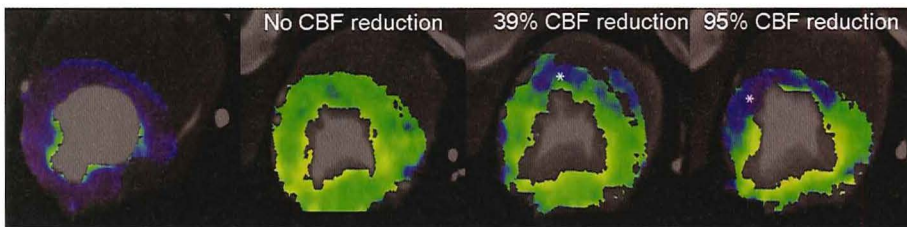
Response of CT-derived myocardial blood flow (CT-MBF) to different levels of coronary blood flow (CBF) reduction. Example of CT-MBF color maps of the myocardium during maximal vasodilation, intermediate CBF reduction and severe CBF reduction. The ischemic area (*) is well visible in the color-map. A progressive decrease of CT-MBF occurs with increasing severity of CBF reduction.
